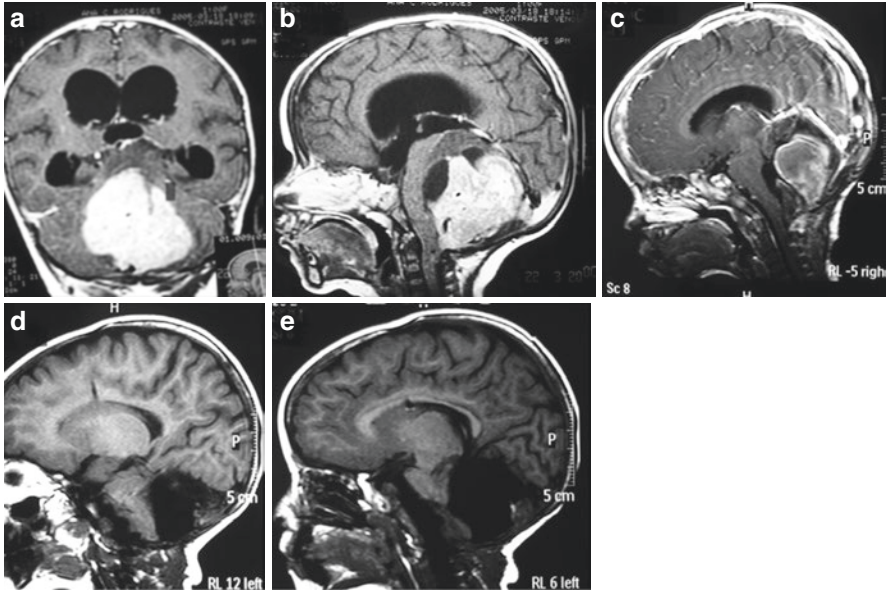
MRI of a 5-month-old female with a posterior fossa ependymoma (a, b). The procedure was interrupted just after obtaining a sample for biopsy, due to profuse bleeding and hemodynamic instability. After chemotherapy, note decrease in the volume and vascularity of the lesion (c) allowing total removal of the mass lesion (d, e)
